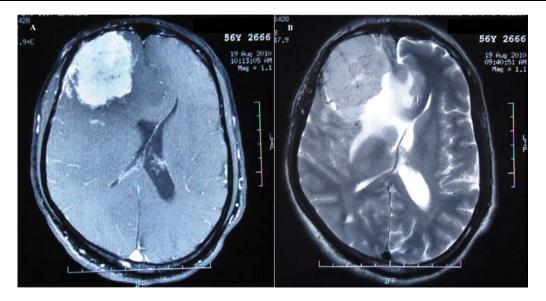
T1 weighted MR image of Angiomatous meningioma showing contrast enhancement and midline shift (A). T2 weighted image showing perilesional edema (B).
